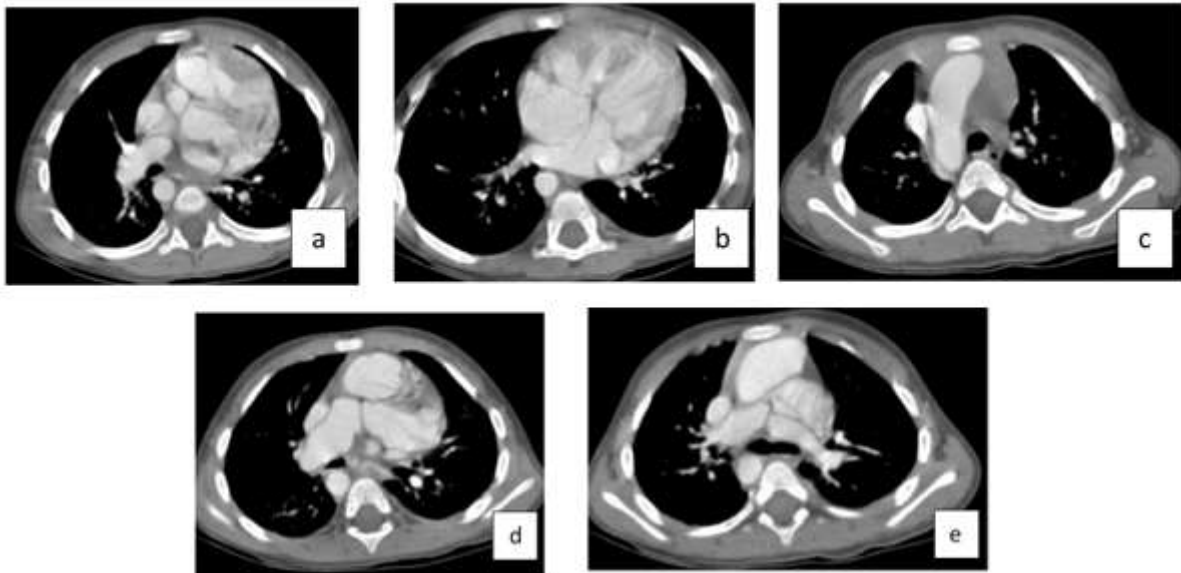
1 year old case of TOF. Axial post contrast cardiac CT images showing : a – anteriorly placed left ventricular outlet (aorta) to right ventricular outlet (suggesting altered relation between great vessels) and overriding of aorta, b – ASD and small VSD, c- right sided aortic arch (with mirror image branching pattern not shown in the image), d- dilated right pulmonary artery and e- left pulmonary artery(likely due to pulmonary stenosis at the level of infundibulum not shown in image causing post stenotic dilatation).
